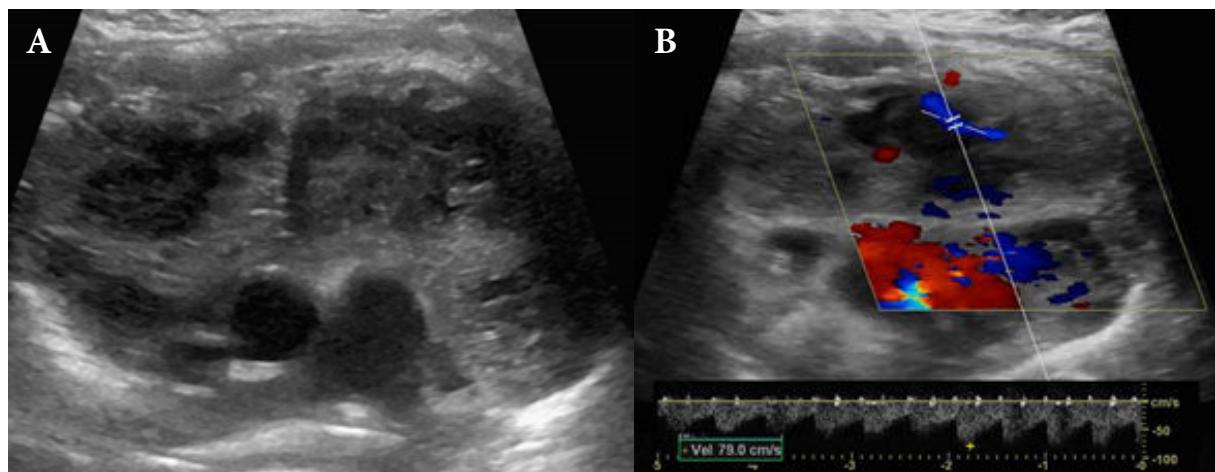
The first follow-up ultrasound at 5-day interval (A) showed decreased size, less echogenicity, and more well-defined border of the multifocal thymus lesions. (B) Vascular flow within the lesion had low-resistant waveform.
